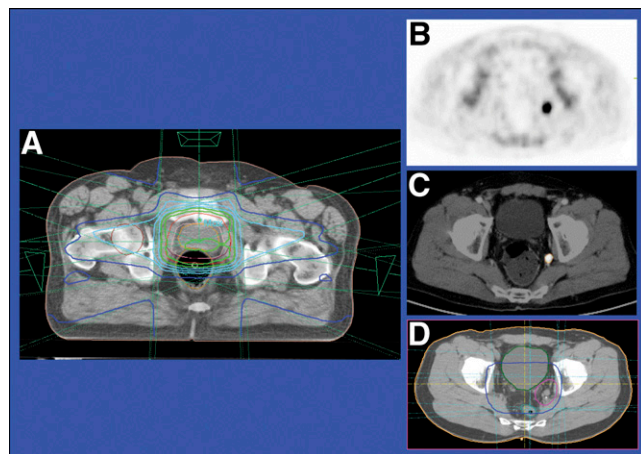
Conventional radiotherapy planning (A) was enhanced by data from PET (B) and CT (C) to provide a more precise PET/CT radiotherapy plan (D).
